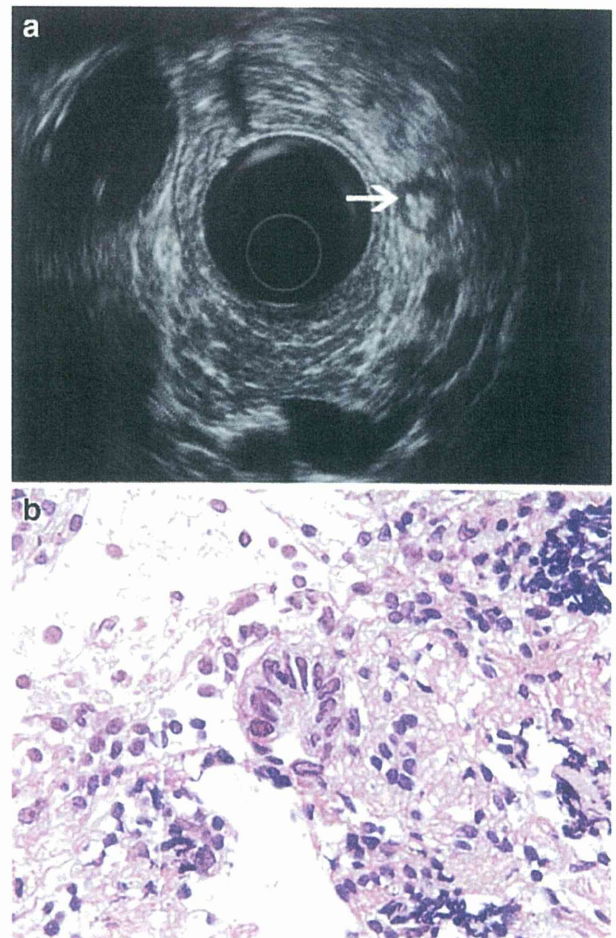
a EUS in May 2009 revealed an enlarged lymph node measuring 12 mm in size at the site previously revealed by CT as well as another lymph node measuring 6 mm in size at a site close to the first one. b An adenocarcinoma with an enlarged nucleus and border irregularities was pathologically revealed by EUS-FNA
